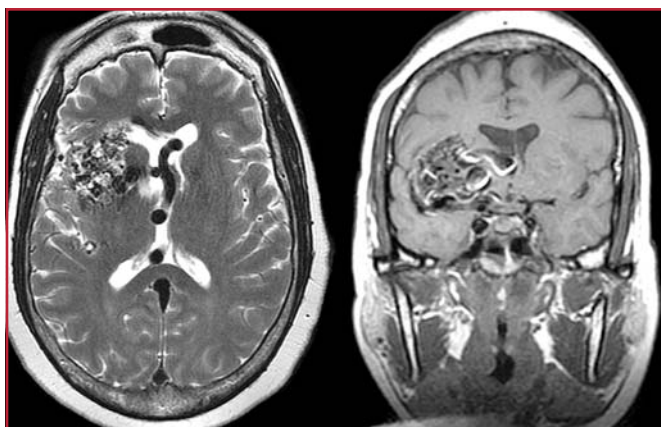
Patient 3. MRI scans showing an AVM in the right sylvian fissure and frontal lobe.
